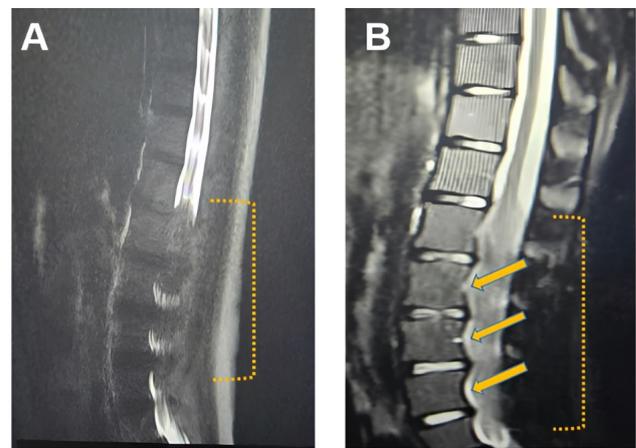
Parasagittal MR myelogram at L1–L5 (A) shows diffuse intradural thickening with hypertrophic, clumped nerve roots extending from L2 to S1, causing near-complete obliteration of the spinal canal. There is loss of the T2-hyperintense CSF signal, reflecting marked canal compression. In the lumbosacral region, the spinal canal is almost completely filled with hypertrophic nerve roots. The T2-weighted sagittal image (B) demonstrates posterior vertebral body scalloping (yellow arrows), indicating chronic remodelling and cortical bone resorption due to longstanding nerve-root enlargement. Sagittal images are included to depict the full craniocaudal extent of nerve-root hypertrophy from L1 to L5.
